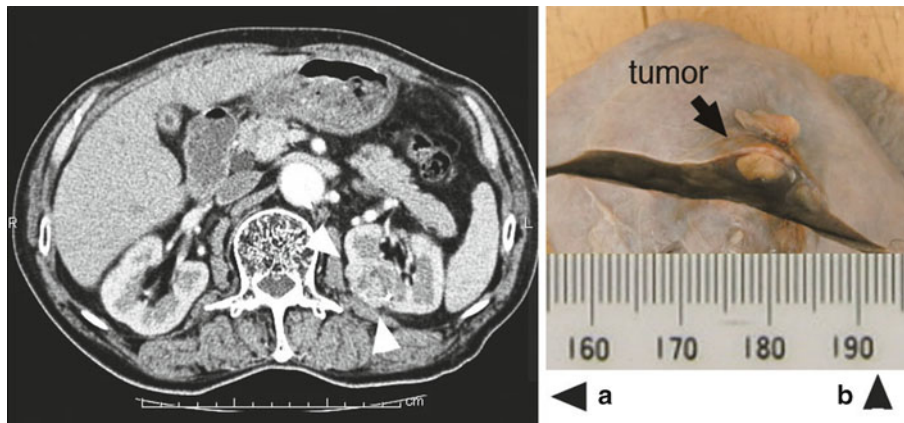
Findings of a patient who died of intercurrent disease. (a) CT just before the treatment for RCC. Initial maximal diameter of the tumor was 3 cm. (b) Macroscopic findings of the tumor at the autopsy (8 months after the carbon ion therapy)
